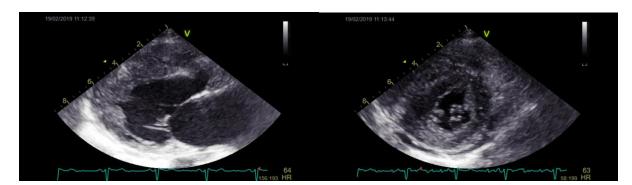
Transthoracic echocardiography with long axis and short-axis view (mid) revealed right and left ventricle hypertrophy
